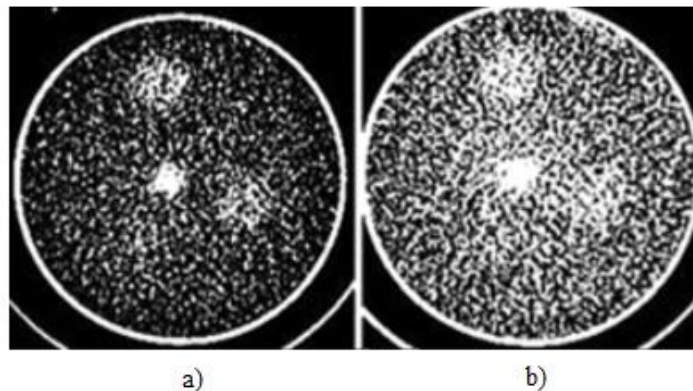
Initial CT image (a); image after 360 iterations (b) - changes in the image becomes apparent due to the CT imaging dose [46].
